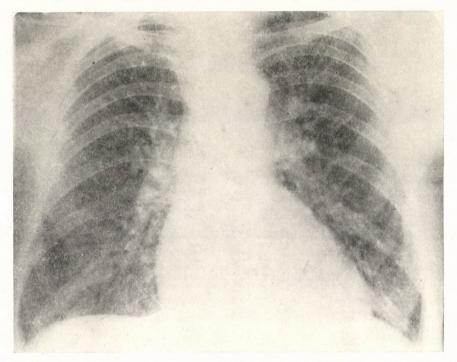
(Case 1). Chest X-rays. Typical polycythaemia vera syndrome in relapse
